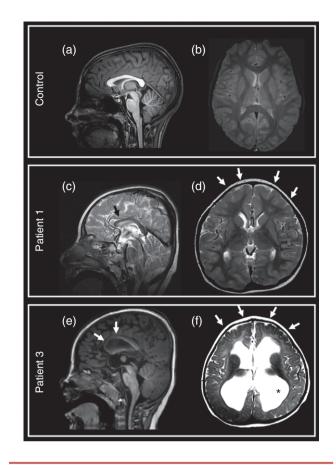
Representative brain magnetic resonance imaging showing the main anatomic abnormalities in two patients in comparison to a normal brain. (a), (c), and (e) sagittal sections passing through the midline and showing the corpus callosum and midline strictures. (b), (d), and (f) axial sections passing through the Sylvian fissures and the lateral ventricles. (a) and (e) T1-weighted images; (b), (c), (d), and (f) T2-weighted images. (c) and (e) demonstrate corpus callosum hypoplasia (arrows). (d) and (f) show a simplified gyral pattern in the frontal lobes (arrows) which also appear considerably reduced in volume. (f) there is also marked enlargement of the lateral ventricles (asterisk), with the basal ganglia and thalami protruding into the ventricular lumen.
